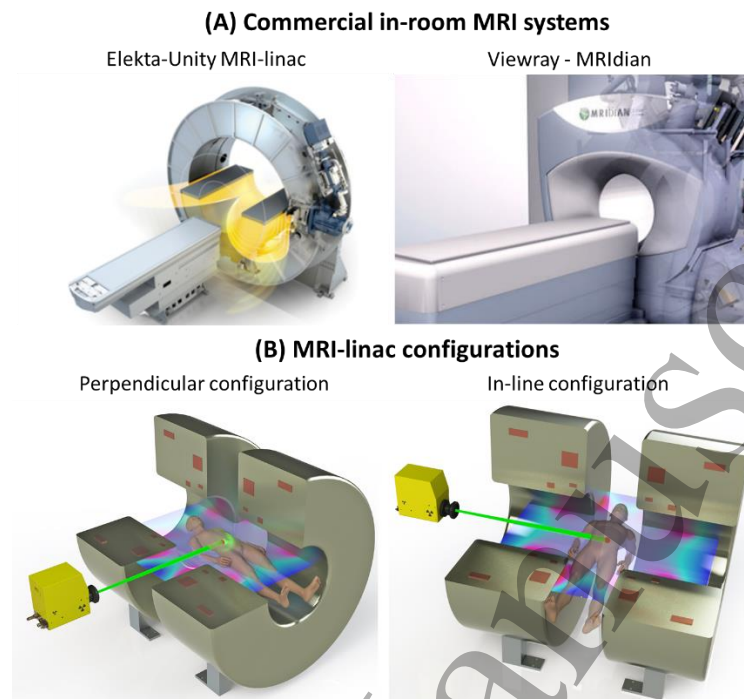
In-room MRI systems. (A) Commercial systems: Elekta-Unity MRI-Linac and Viewray MRIdian. (B) MRI-Linac configurations: MRI-Linac systems can be constructed in either the perpendicular configuration, or the in-line configuration (the images shown here are based on the Australian prototype system, which was designed to facilitate operation in both configurations).
